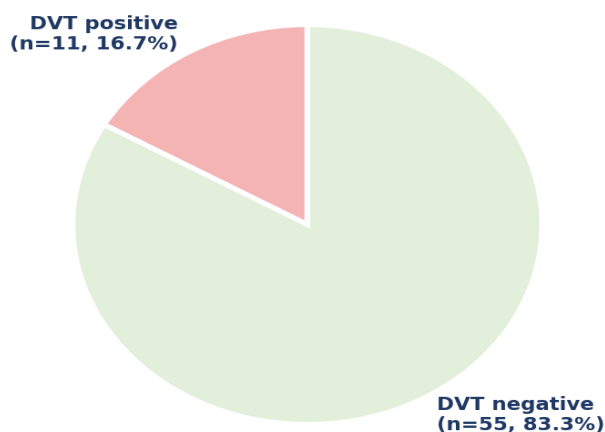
Incidence of DVT among the study cohort (n = 66). Eleven patients (16.7%) had ultrasonographically confirmed lower-limb deep vein thrombosis.
